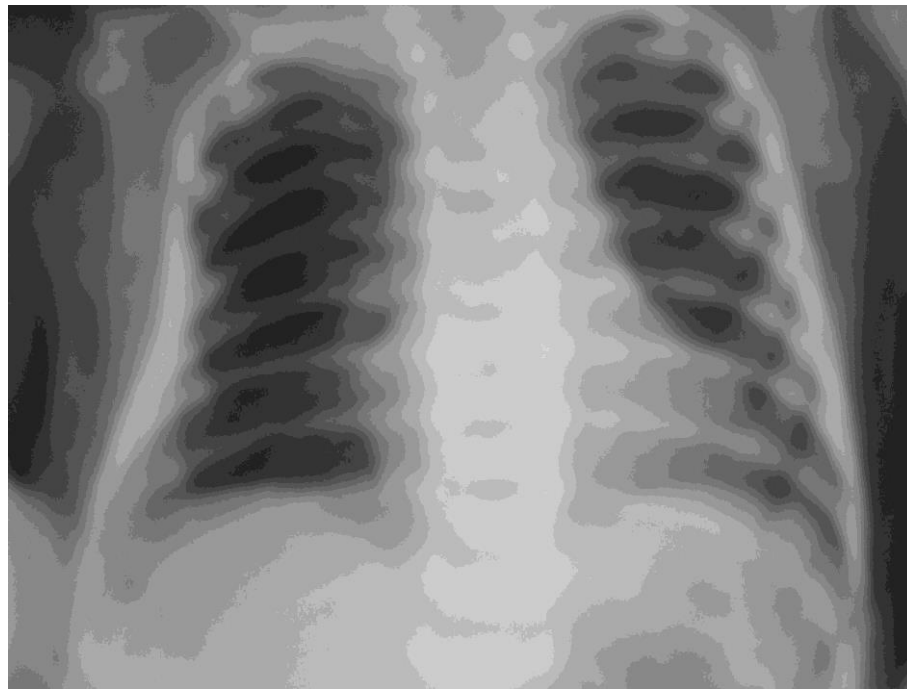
Radiograph of child Sh. during treatment dynamics, 17 days. Residual effects after polysegmental pneumonia. Airy lung fields. Nodose-reticular mesh in limited areas in the middle zones. Single widespread small-focal shadows. "Air bronchogram" symptom.
